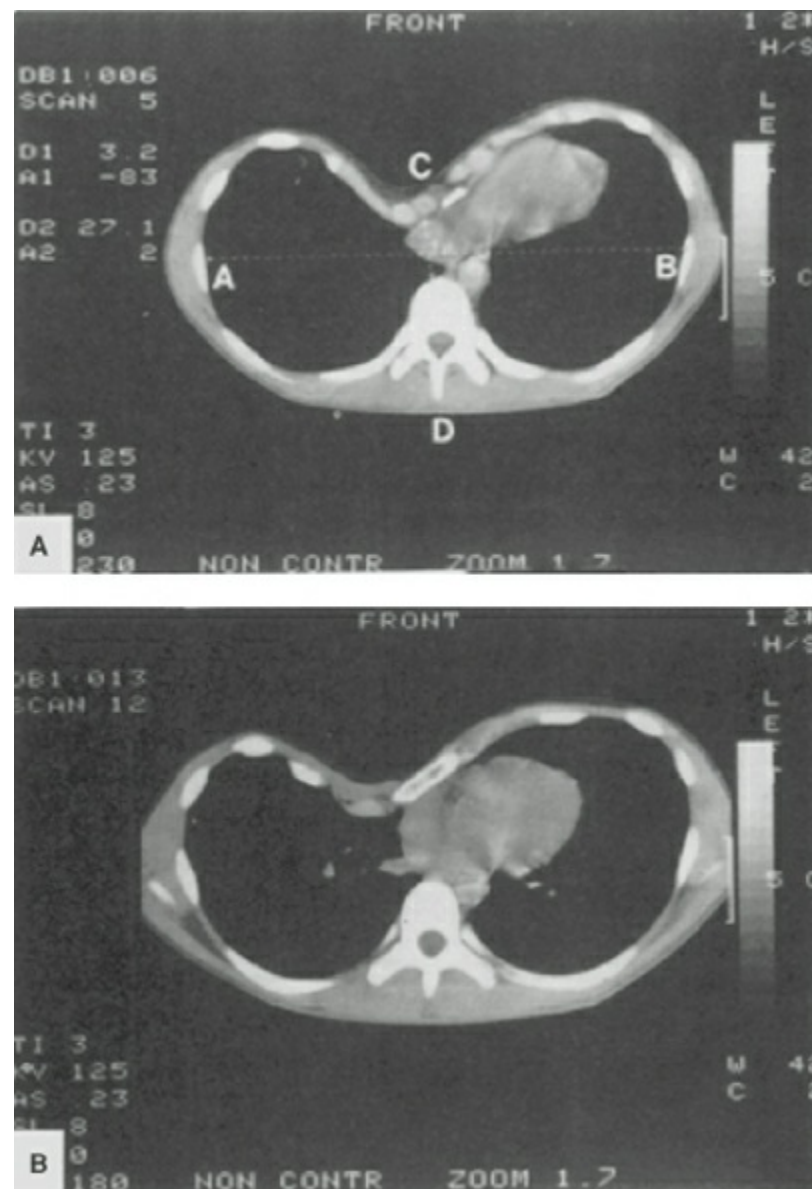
Chest CT of pectus excavatum. CT image at xiphoid with A-B (transverse diameter) and C-D (anterior-posterior diameter) indicated for the calculation of the pectus severity index $A-B/C-D$ (A). CT image demonstrating angulation of the sternum to the right in the severe defect (B). (Reproduced with permission from Haller JA Jr, Scherer LR, Turner CS, et al. Evolving management of pectus excavatum based on a single institutional experience of 664 patients. *Ann Surg* 1989;209(5):578–582.)
